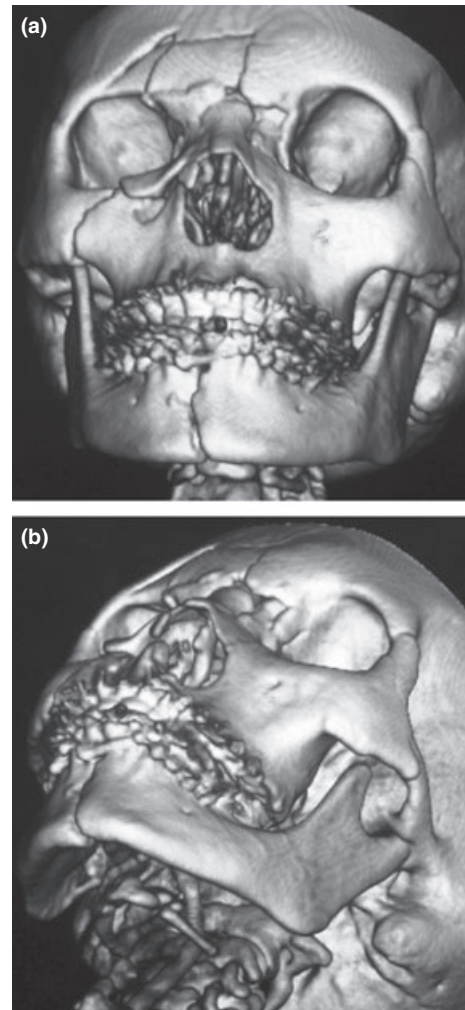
Postoperative three-dimensional computed tomography (CT) presents superolateral dislocation of intact mandibular condyle. (a) CT demonstrated a closed reduction in the panfacial fracture. (b) An accurate reduction in the left condyle in a CT can be observed.
